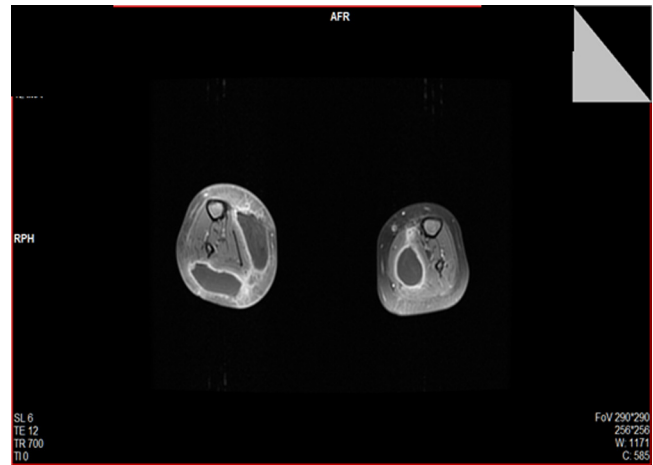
The MRI images – pyomyositis areas in the crural muscles, cross-section
